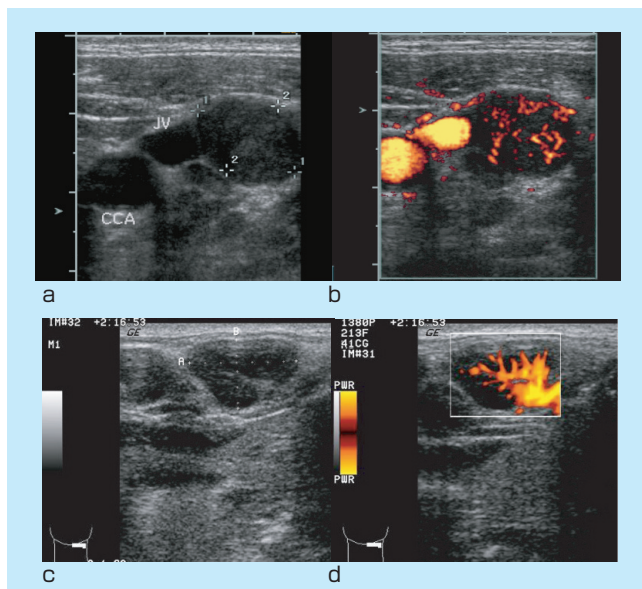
Ultrasonograms of lymph nodes positive (a, b) and negative (c, d) for metastasis
